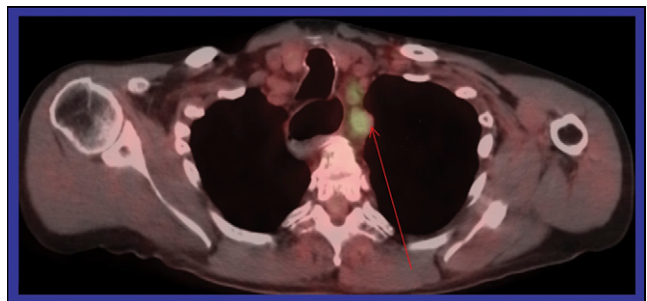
^{18}F -FDG PET/CT detected extramedullary disease in the paratracheal node in this patient with multiple myeloma.
